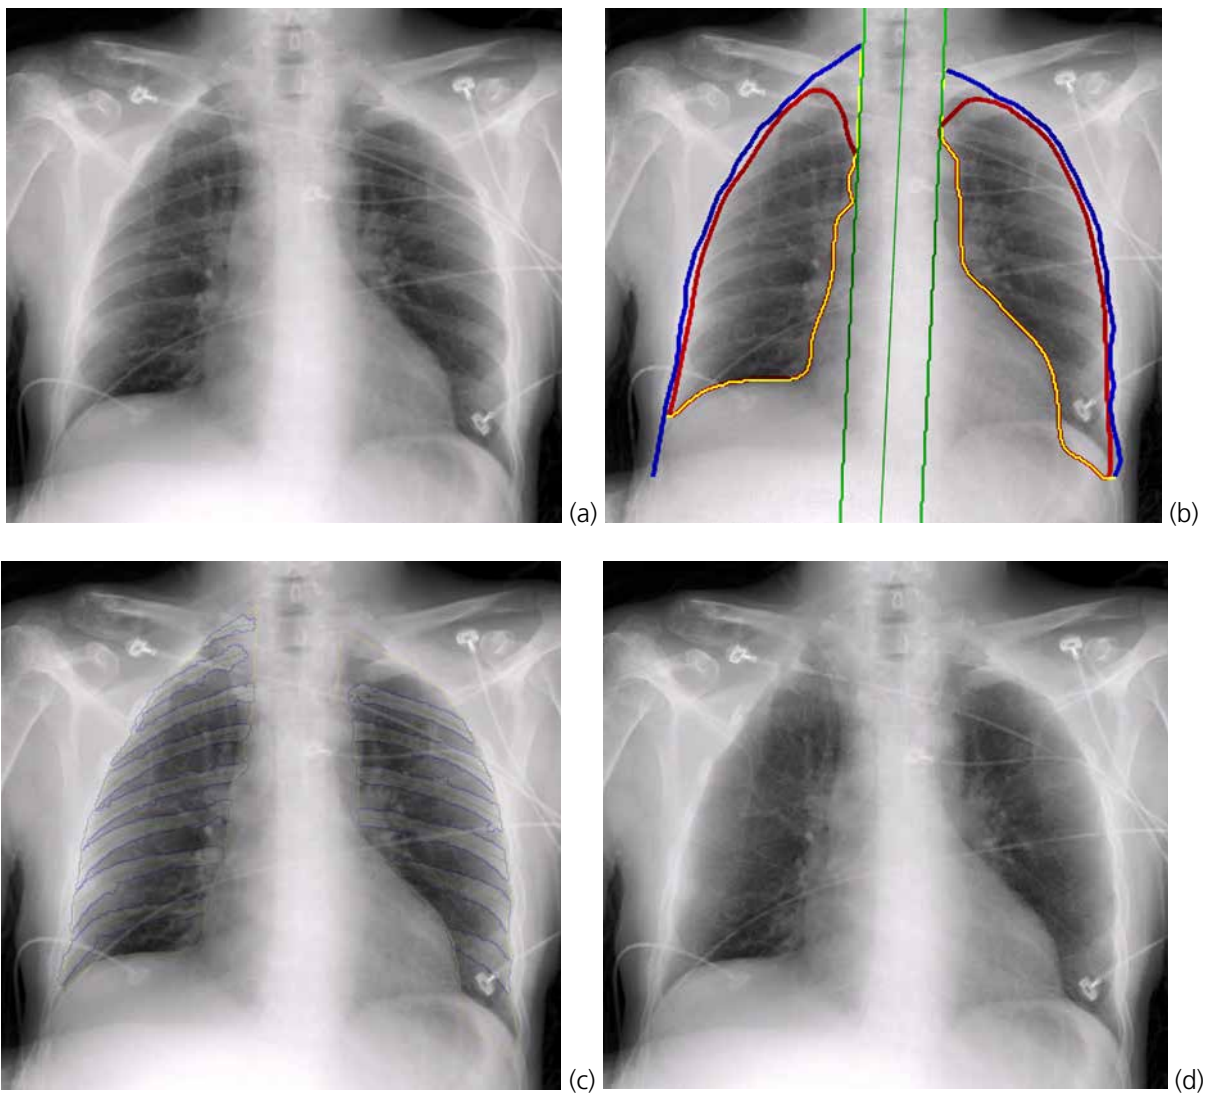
a) An input portable chest radiographic image; b) the image with segmented lung field; c) the image with detected ribs; and d) the image with ribs suppressed.
